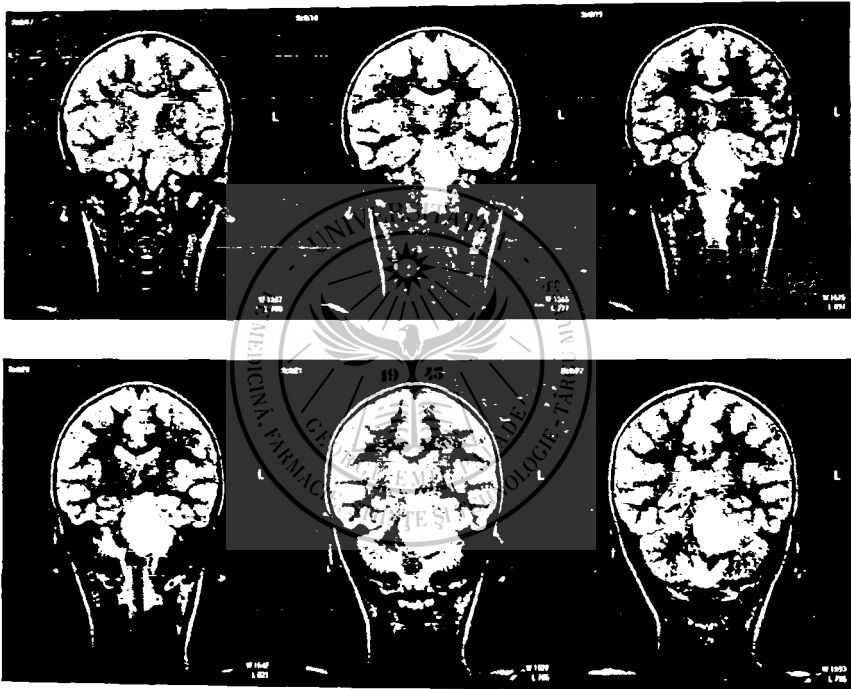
Preoperative,coronal, postcontrast serial MR images in patient R. G.
